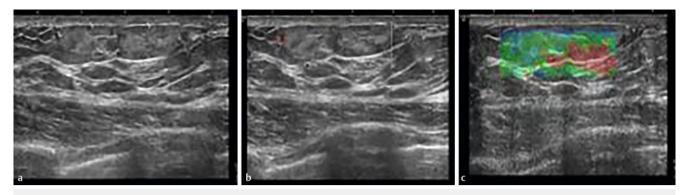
a Fibrolipomas. Two oval subcutaneous focal findings that are isoechoic and hyperechoic and have distinct borders on ultrasound. b No evidence of flow on Doppler ultrasound. c Soft to medium hard presentation on elastography.
